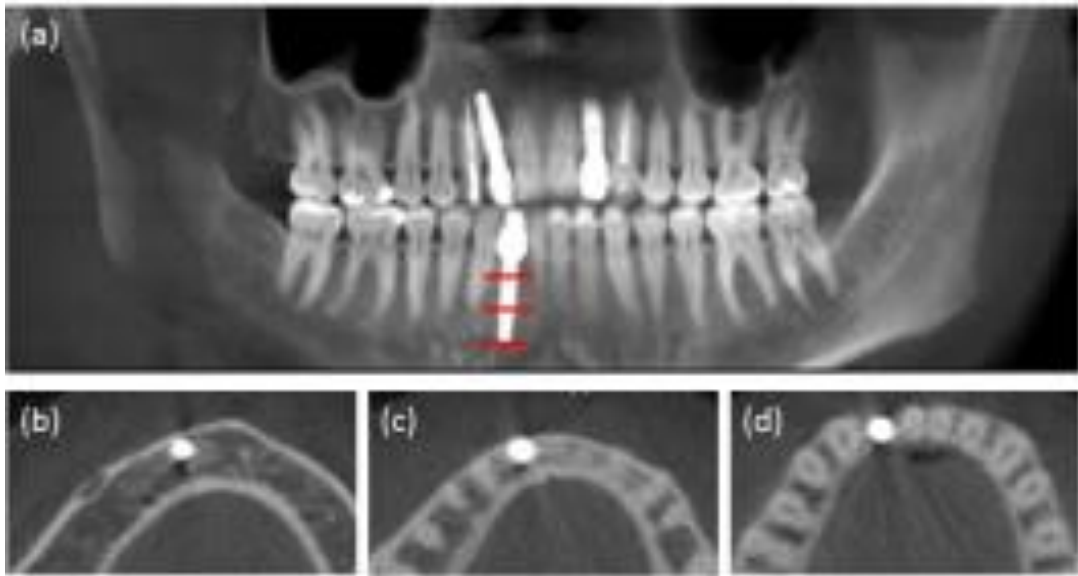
(a) CBCT panoramic slices showing the apical (b), middle (c) and cervical (d) slices of an implant installed in the mandible.
